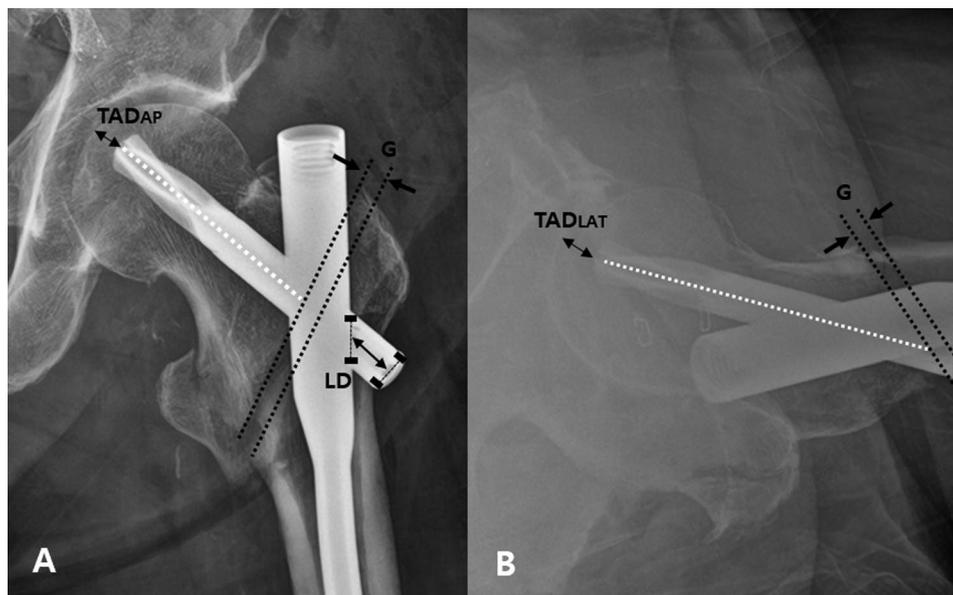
Radiographic measurements performed in this study. (A) (B) The tip-apex distance is measured as the sum of the distance, in millimeters, from the tip of the lag screw to the apex of the femoral head in the anteroposterior and lateral view of the radiographs. The lateral extension distance (for screw back-up) was measured between the lateral end of the screw and lateral edge of the intramedullary nail. The gap of the cortical bone (G) was measured as the maximum value of the gap observed in the anteroposterior or lateral view
